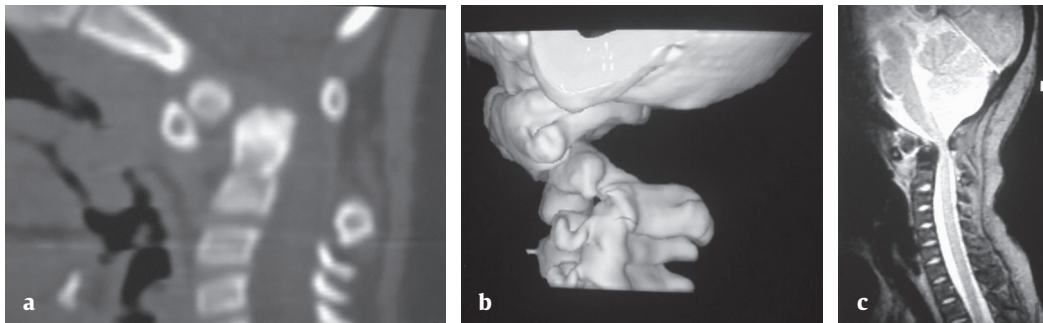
Os odontoideum. (a): CT showing bony invasion of the cervical canal; (b): CT-3D spinal malalignment associated with os odontoideum; (c): MRI confirming severe compression to the spinal cord.
